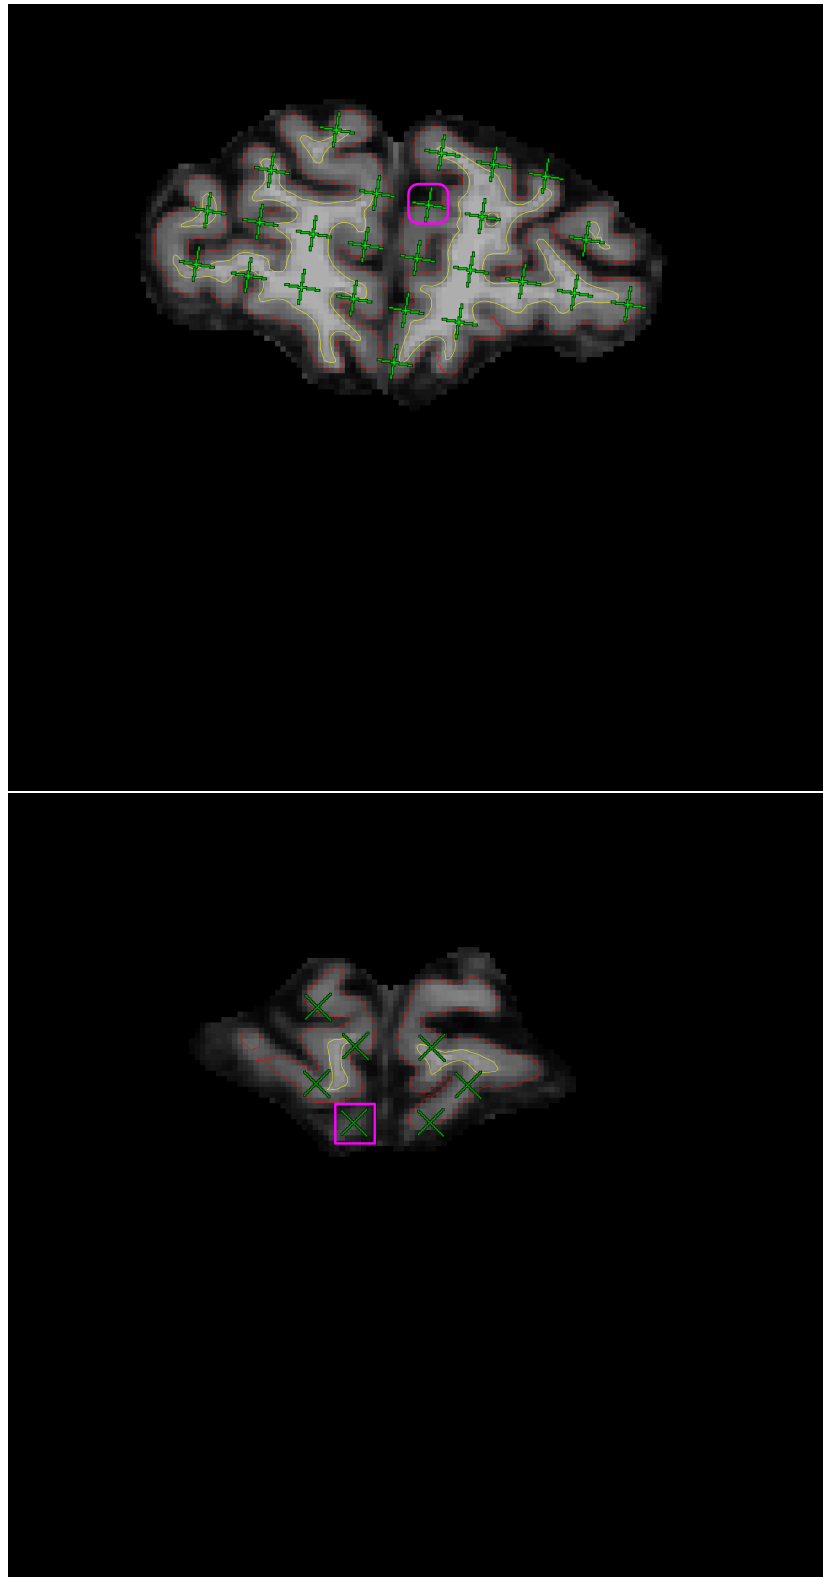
On the 15th and 16th slices of one brain MR image in the coronal view, counted test points (green) hitting the cerebrum (excluding ventricles) are overlaid onto pial profiles (red lines) segmented by FREESURFER. Rectangles (pink) mark the counted test points which fall outside the grey matter boundaries (red lines) and rounded rectangles (pink, racetrack-like) mark the test points hitting exactly on the grey matter boundaries.
